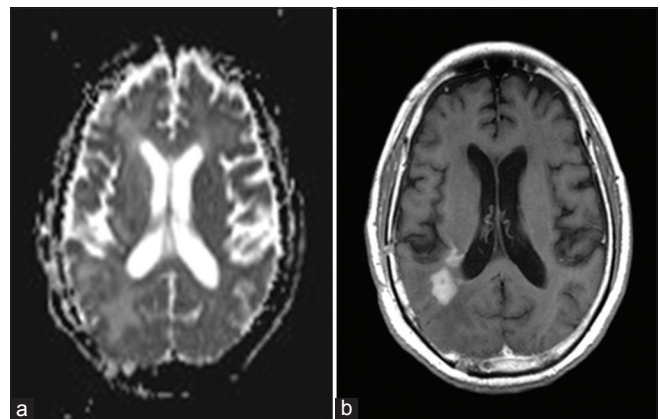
Magnetic resonance images of PCNSL patients. (a) The axial image of ADC showed that the parenchyma of the right parietal lesion was markedly enhanced. (b) At the corresponding level of ADC image, the enhanced part of the lesion showed low signal in the ADC image
